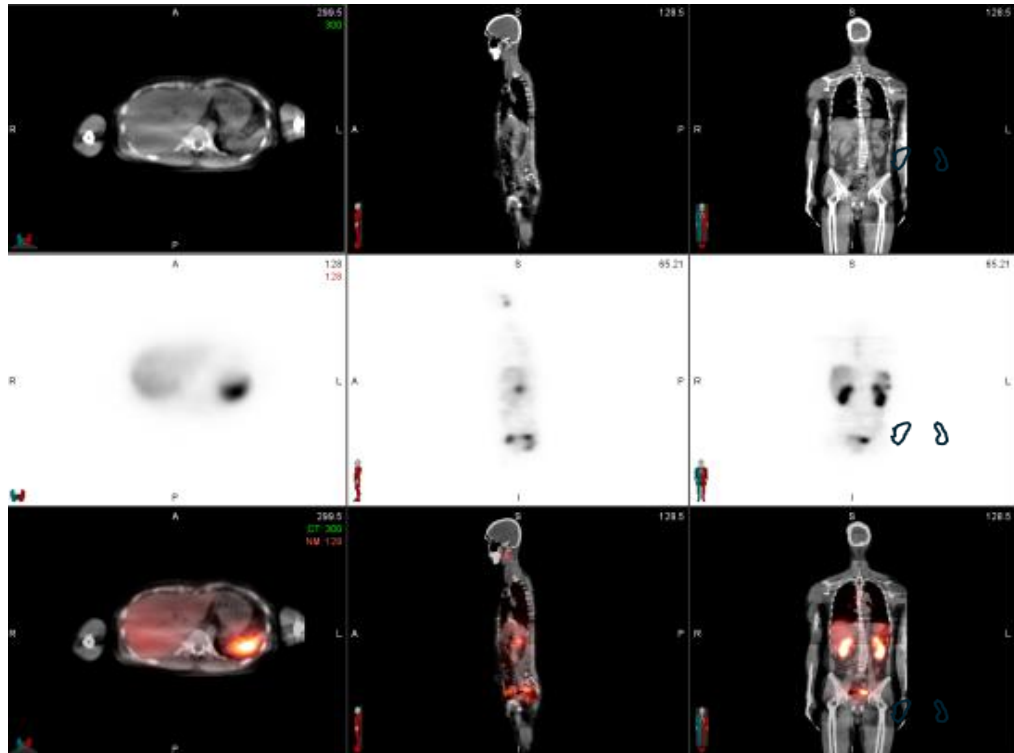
SPECT/CT imaging of a patient post MRT showing axial, sagittal, and coronal views.
